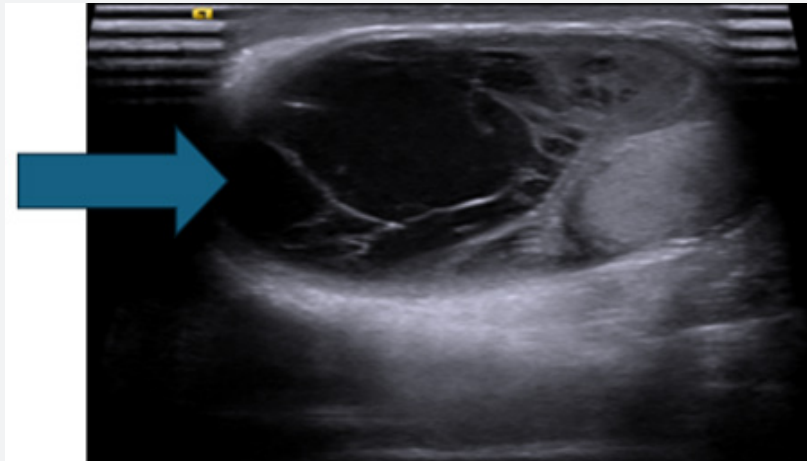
U/S Doppler increased amount of the left scrotal fluid collection with multiple septations and echogenic debris.
